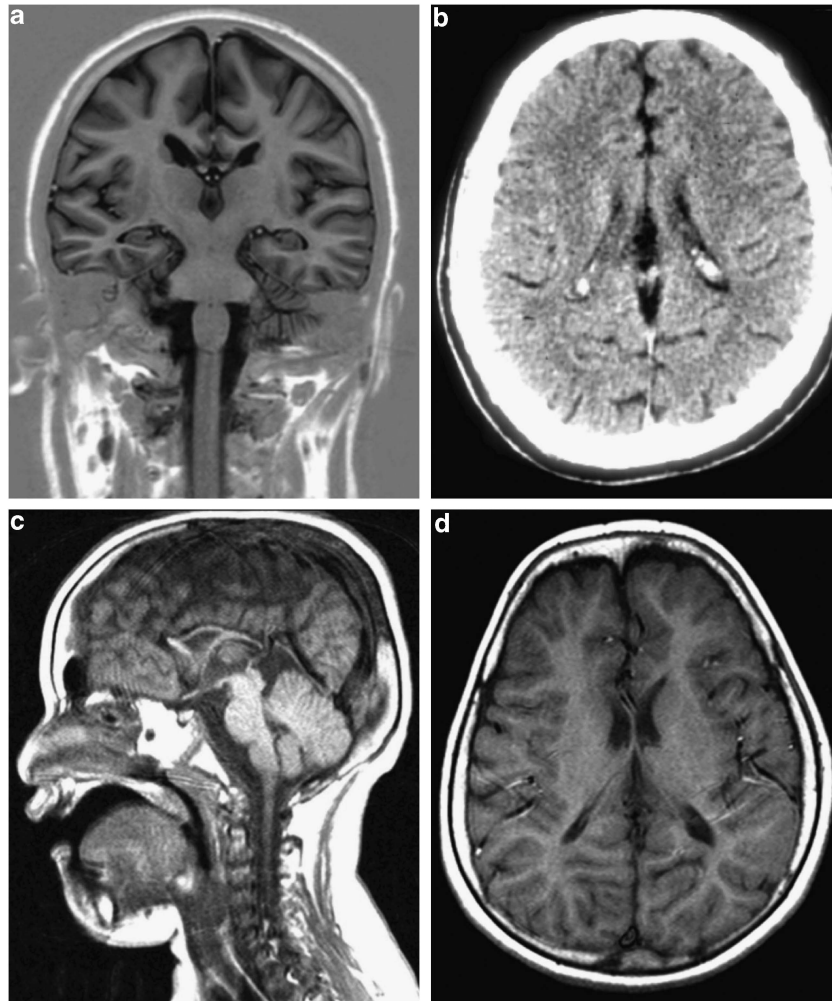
Cranial MRI/CT scans of DDHD2 patients. MRI/CT scans of DDHD2 patients show dysgenesis of the corpus callosum as well as some paucity of the periventricular white matter (d). (a): coronal MRI (T1 inversion recovery) of THI26003-4. (b): axial CT-scan of THI26003-3. (c): sagittal MRI (T1) of IHG25194-3. (d): axial MRI (T1) of IHG25194-3.
